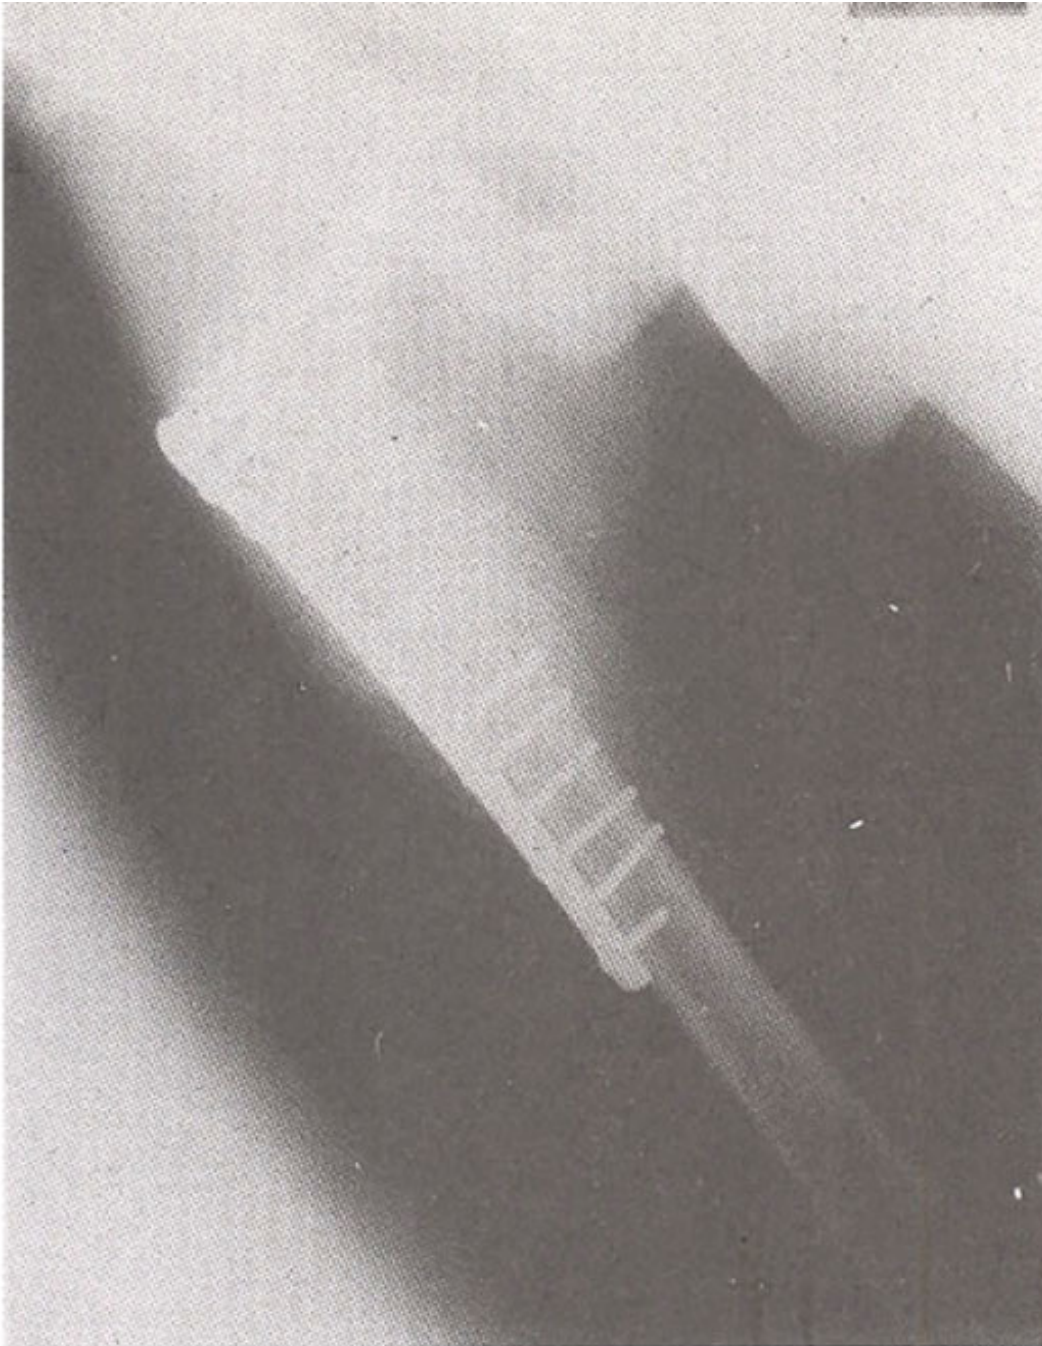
The fracture was debrided four times and then fixed with a reversed D.C.S. and bone grafted X-ray at 6 months showing good union.
